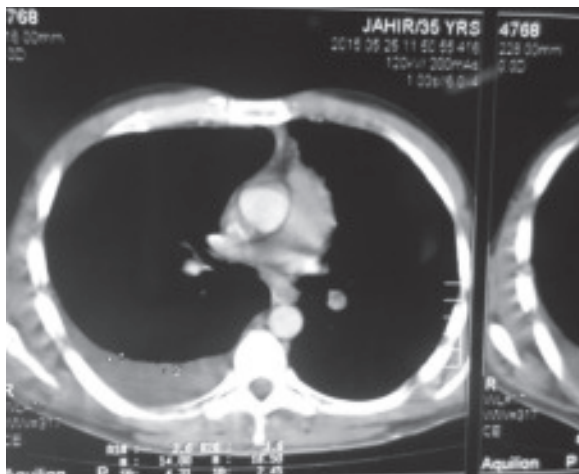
CT scan of chest showing right-sided pleural effusion.
